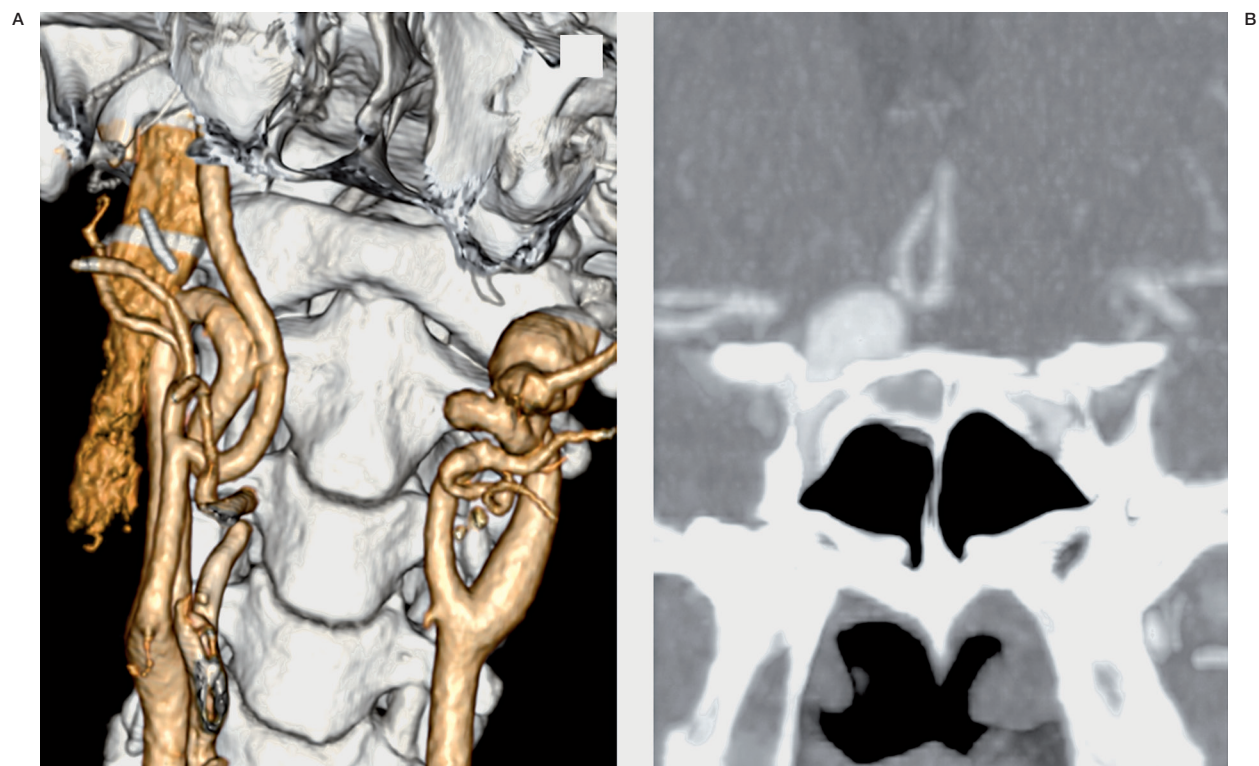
CTA finding of a styloid process causing a false aneurysm of the left ICA, elongation of both proximal parts of the ICA and a large aneurysm of the supra-ophthalmic part of the right ICA (A,B).
